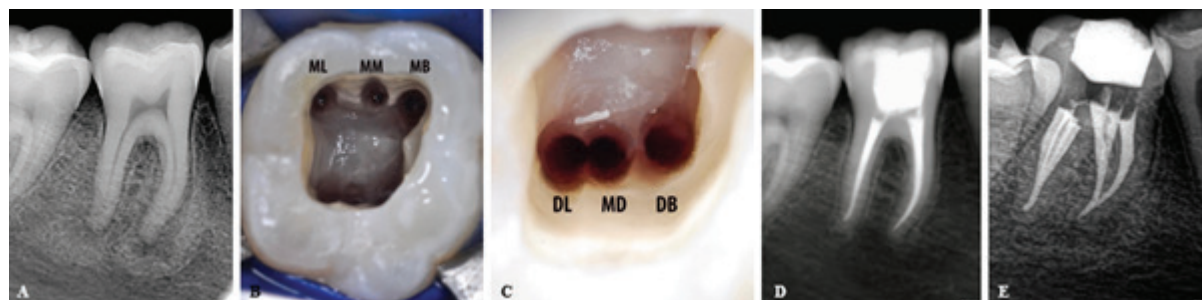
The clinical management of a mandibular first molar with an MM and MD canal; (A) Pre-operative periapical radiograph of a non-vital right mandibular first molar that presented with periapical pathology around the mesial and distal roots; (B) Magnified view of the pulp chamber showing the MB, MM and ML canal orifices after canal preparation with ProTaper Universal instruments (Dentsply Sirona); (C) High-magnification view of the distal aspect of the pulp chamber showing the DL, MD and DB canal orifices after canal preparation; (D) Postoperative periapical radiograph of the obturated canal systems; (E) Mesial angulated postoperative periapical radiograph showing the six obturated root canal systems (3-2-1 configuration in mesial root and 3-1-1 in distal root).
